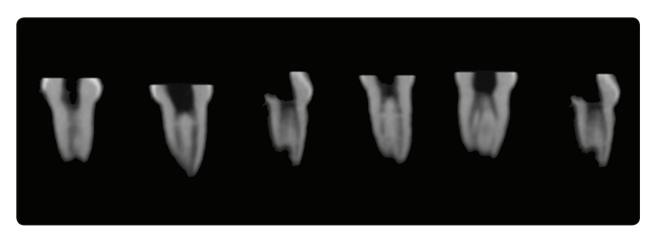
CBCT showing type I & type II mesial root lower E, type IV mesial root lower E, Non-Vertucci mesial root lower E & type II distal root lower E
